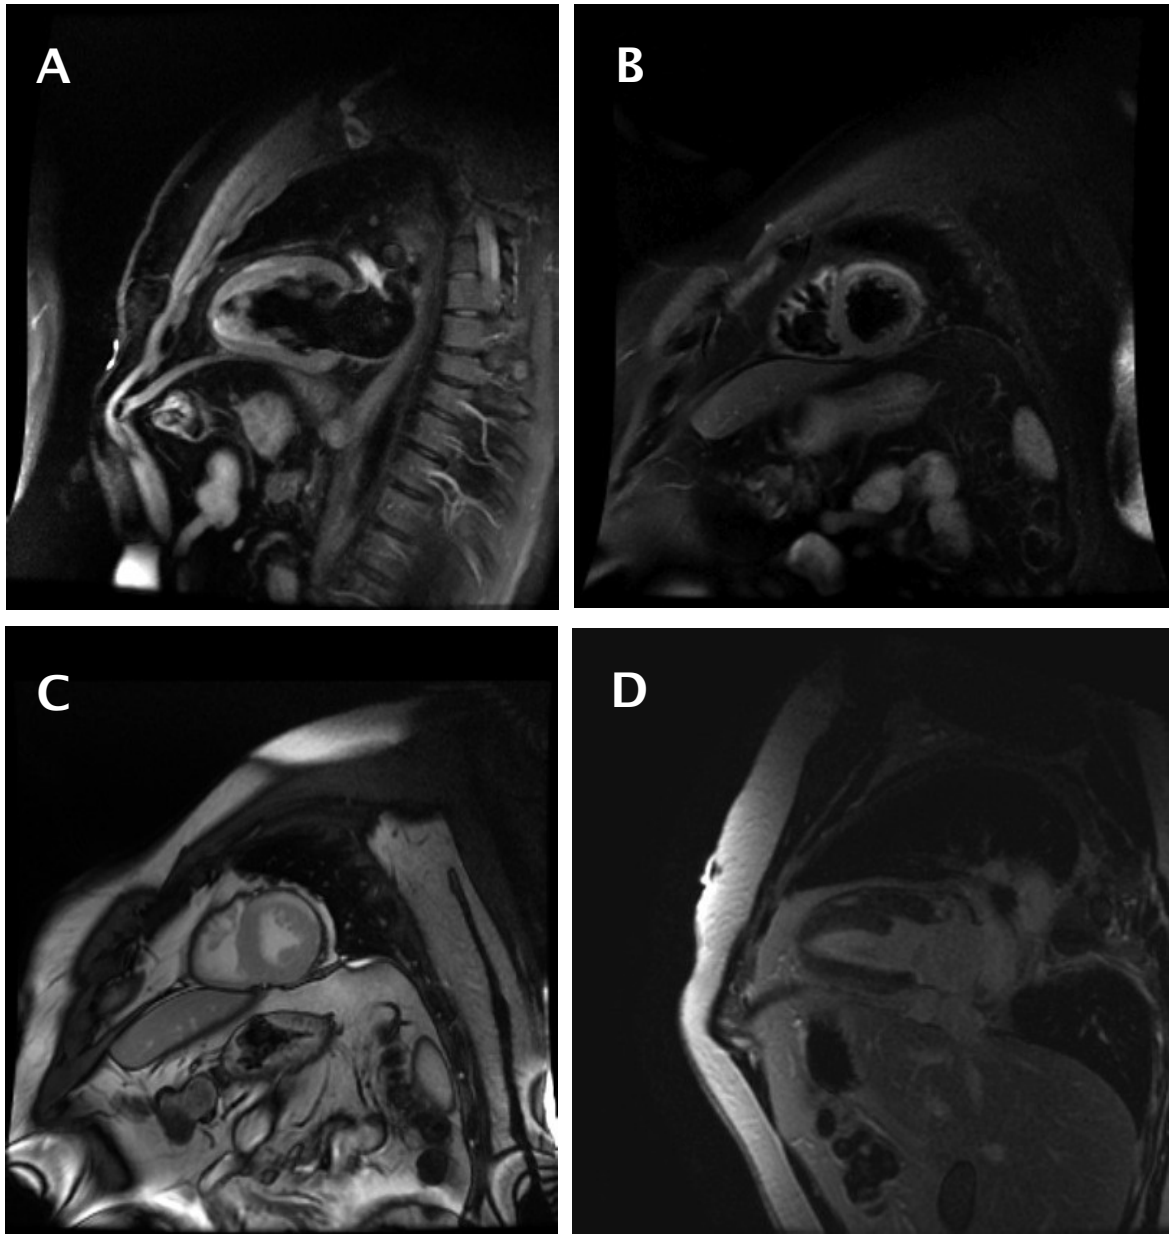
2B-2C-2D: Focal acute myocarditis. T2-weighted short-tau inversion-recovery (STIR) on vertical long axis of the left ventricle (A) and short axis of the mid-left ventricle (B). Cine MRI, using the post contrast b-SSFP technique (C) and CE-IR MRI with late imaging on vertical long axis (D). T2-w STIR images show homogeneous subepicardially hyperintense area in the mid antero-Left Ventricle wall (A,B) expression of edema; the same area of hyperintensity is seen on the SSFP images (C). Strong enhancement is seen in the subepicardial layers of the mid anterior wall (D).
